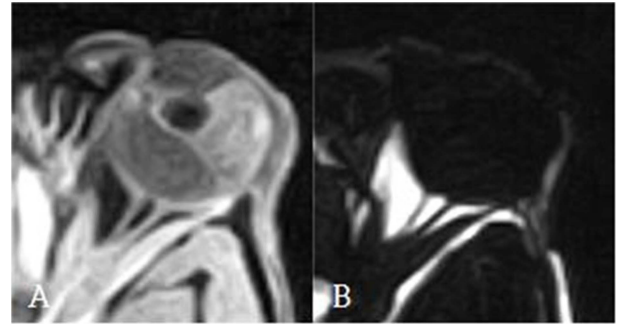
Ciliary body mass and optic canal by Water-fat separation images. (A) Fat suppressed T1-weighted (B) Water suppressed T2-weighted images. There was no evidence of invasion into the surrounding tissues or optic nerve.
